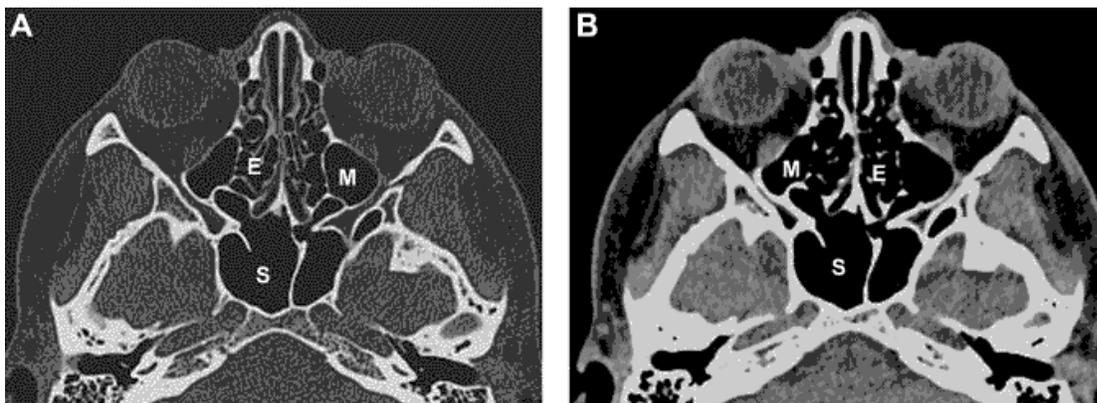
Axial CT scans of the paranasal sinuses at the level of the ethmoid sinuses, (A) bone algorithm and (B) soft-tissue algorithm images demonstrating the importance of visualizing paranasal scans using the two different window image processing techniques. The bone algorithm windowing helps to better evaluate the bony structures such as the walls of the sinuses as well as cartilage bounded by nasal or sinus lumen. The soft-tissue algorithm and windowing help to better evaluate the adjacent soft-tissue structures. Also, note that the posterior walls of the paranasal sinuses, which are oriented at or near the coronal plane, can be better assessed on the axial scans than in the coronal images. M, maxillary sinus; E, ethmoid sinus; S, sphenoid sinus.
